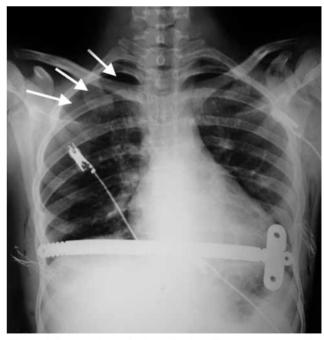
Pneumothorax is shown in chest X-ray on postoperative first day.
